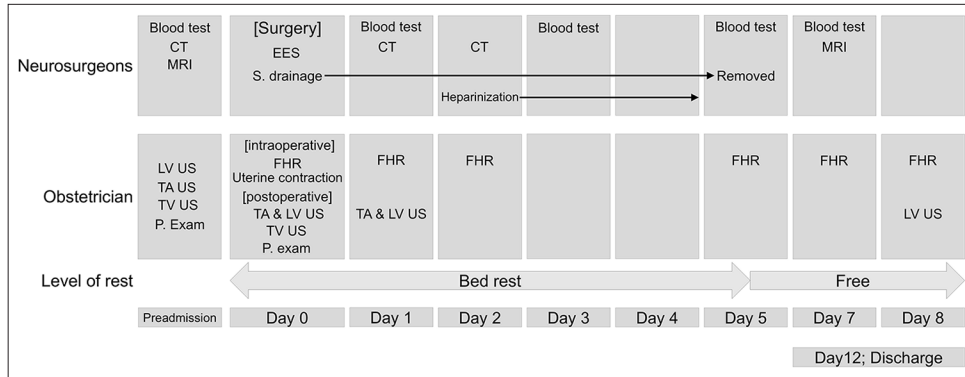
Neurosurgical and obstetrical perioperative management of endoscopic endonasal surgery for a pregnant woman with a tuberculum sellae meningioma in the third trimester. CT: Computed tomography; MRI: Magnetic resonance imaging; LV US: Lower limb venous ultrasonography; TA US: Transabdominal ultrasonography; TV US: Transvaginal ultrasonography; EES: Endoscopic endonasal surgery; P exam: Pelvic examination; S drainage: Spinal drainage; FHR: Fetal heart rate monitoring.
